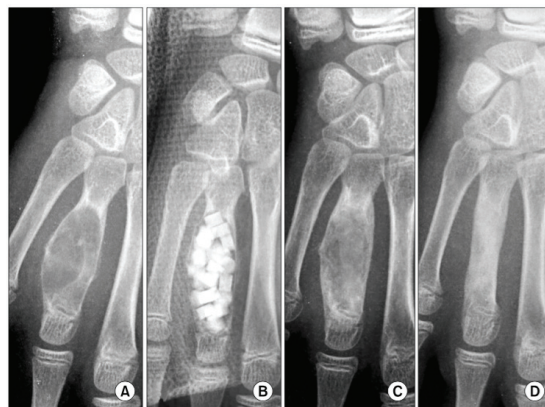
Follow-up of an aneurysmal bone cyst located in the metacarpal bone from pre-operation to 5 months post-surgery. Plain X-rays before implantation (A), after the curettage and grafting of bone substitutes (Osteoset®) (B), 4 weeks (C) and 5 months (D) after the surgery with resorption of bone substitutes and complete bone healing (adapted from Jung et al. 2014).
